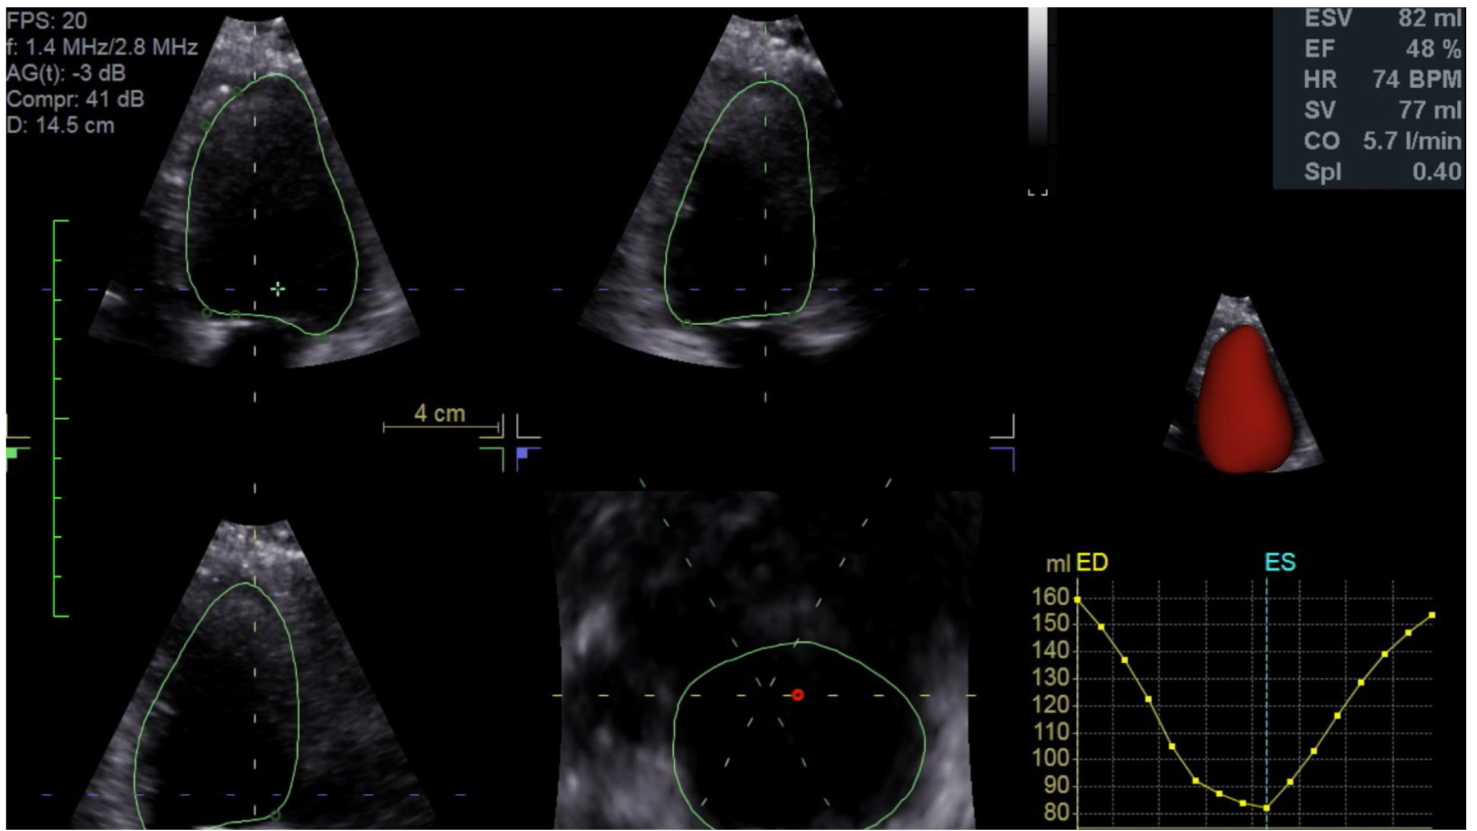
Echocardiogram 3 months after CRT redo reflecting normalized LV function.
